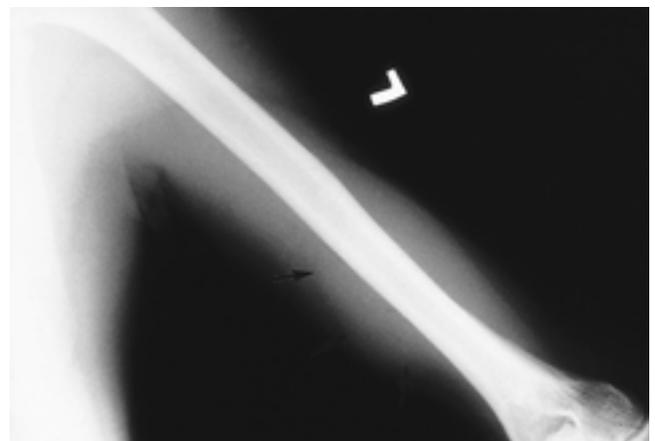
The plain film shows a relatively well-defined soft tissue density mass lesion in the left upper arm (arrow). There was no evidence of bony change.
